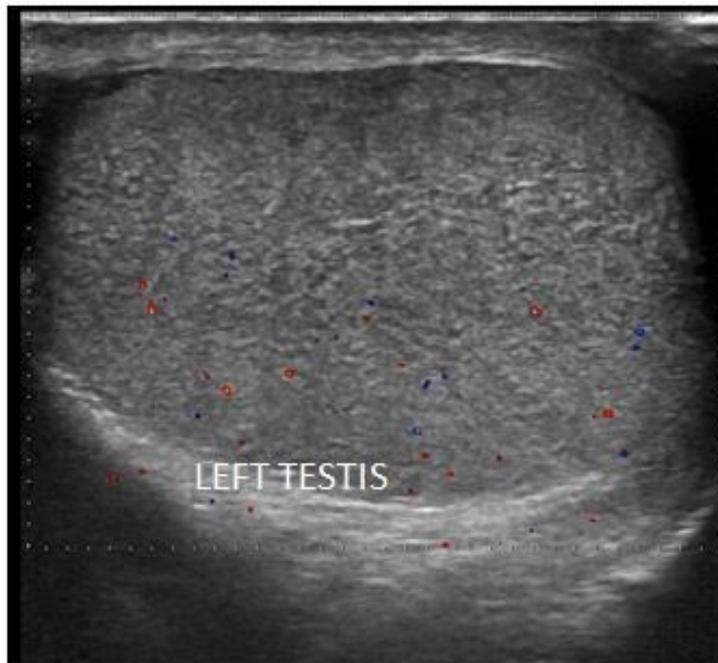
and 3 Longitudinal color Doppler and power Doppler scans shows absent flow in the left testis.
